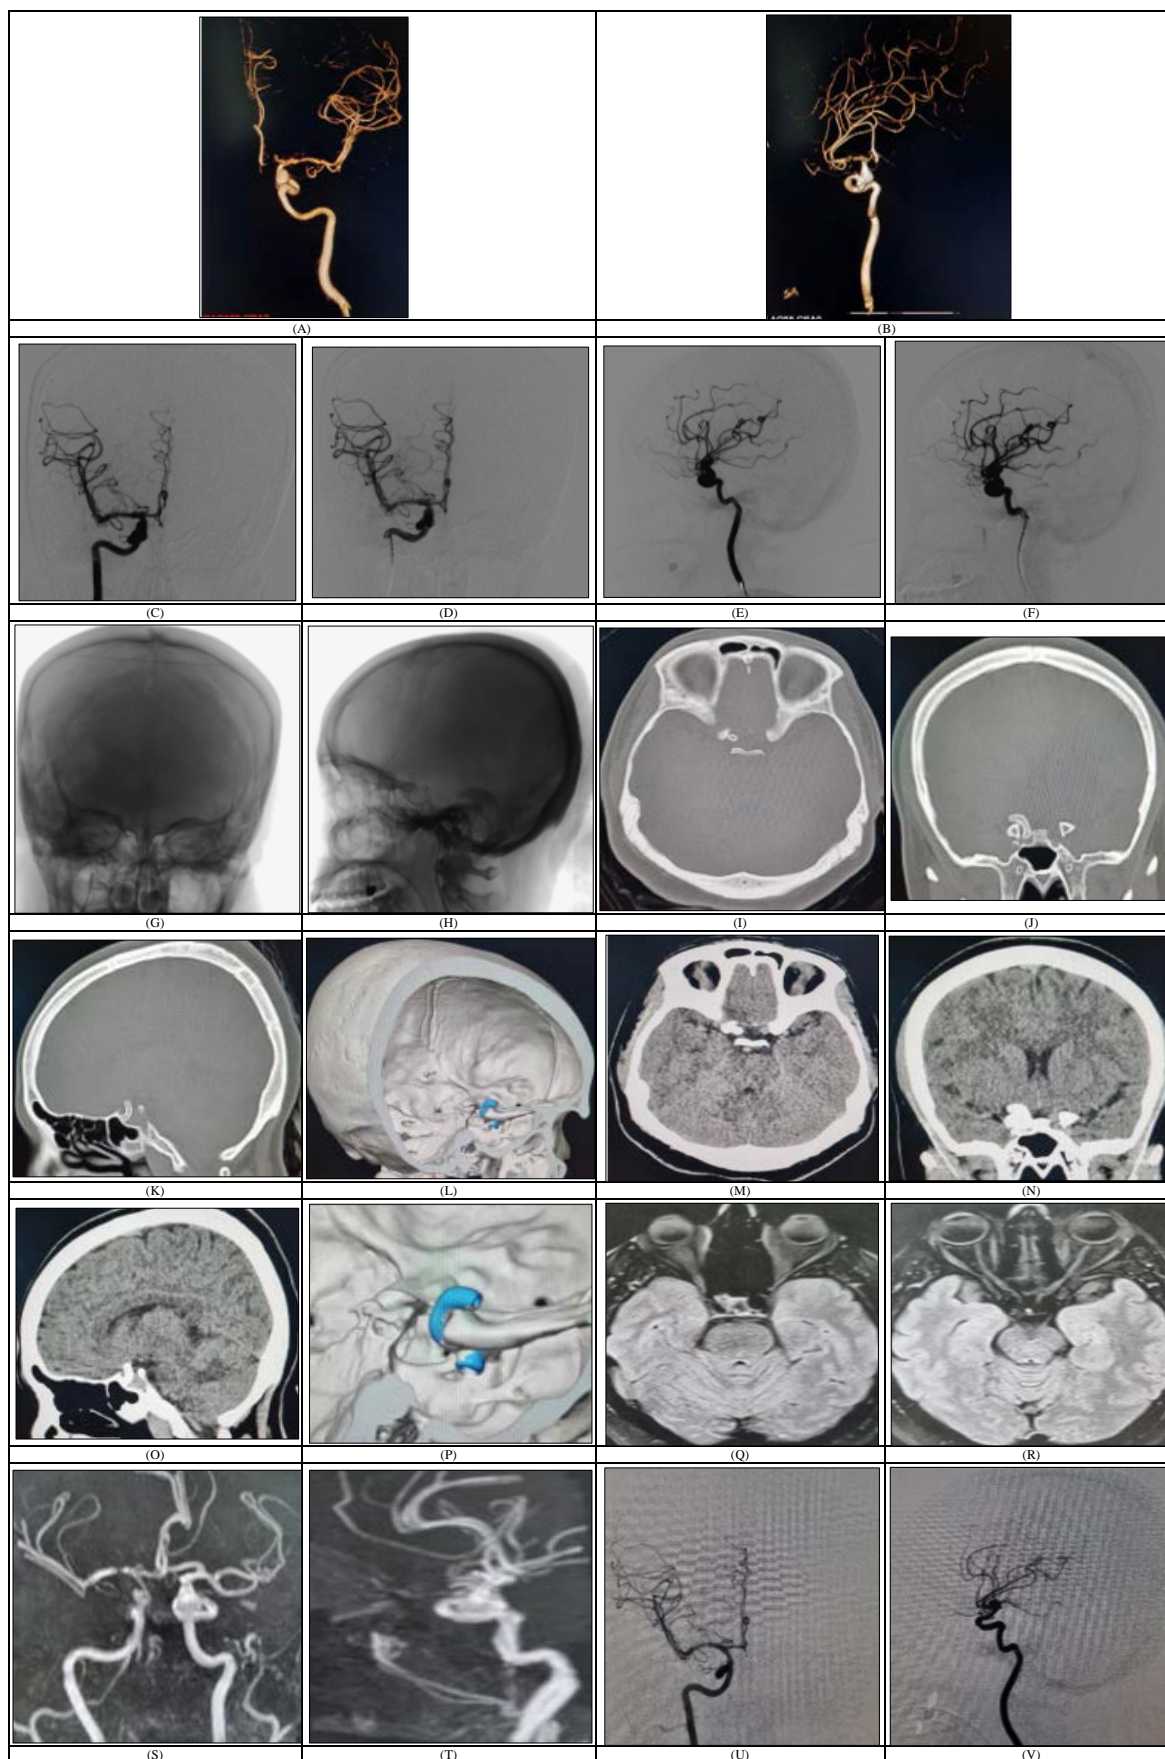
(A, B) 3D reconstruction of the right internal carotid artery (ICA) angiogram in different angles showing the aneurysmal neck and its relation to the ICA, pre-diversion (C) and post-diversion (D) Right ICA angiogram in the AP view. Pre-diversion (E) and post-diversion (F) Right ICA angiogram in the lateral view. Fluoroscopic images (AP (G) and lateral (H) views) showing the flow diverter, which is more evident in the lateral view. Post-operative head CT, bone window (axial (I), coronal (J), sagittal (K) and 3D reconstruction (L)) showing flow diverter in the para-clinoid region. Post-operative head CT, brain window (axial (M), coronal (N) and sagittal (O)) and a close-up view of the 3D reconstruction (P) showing flow diverter in the para-clinoid region and no intracranial hemorrhage. MRI of the brain (axial FLAIR (Q and R)) and cerebral MRA (S and T) at 6 months. Follow up DSA at 12 months, right ICA angiogram (AP (U) and lateral (V) views) showing complete aneurysm occlusion
